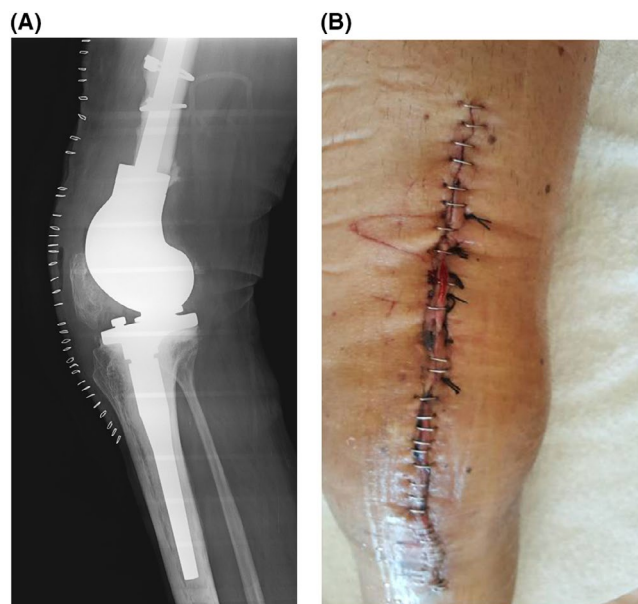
Figure 1, A Lateral radiograph of the long-stem tumoral prosthesis implanted in the left knee due to severe loosening of the primary prosthesis. B, Left knee on day+3.
